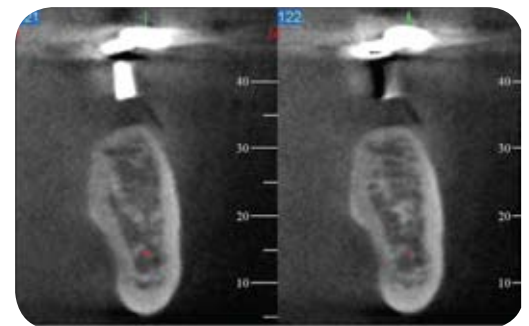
NewTom volumetric scan of patient with the radiographic template (sagittal view). The template indicates proper angulation and direction for implant placement. Note the excellent bone volume and position of the mandibular canal.
